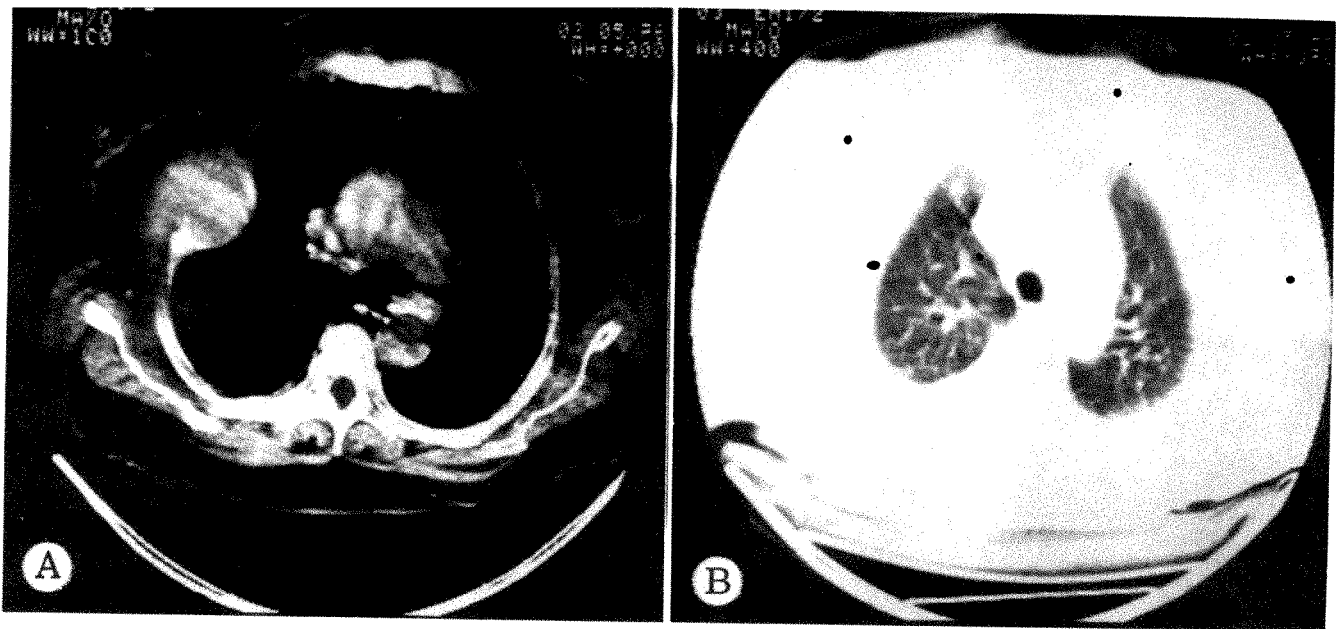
CT scans of 79-year-old woman who had subtotal thyroidectomy 3 years earlier for papillary adenocarcinoma. Destructive lesion had recently developed in right third rib and in right side of pelvis. *A*, Tomographic section through chest revealing large destructive lesion in rib on right. Large portion of mass projects into chest and tumor extends considerably into chest wall. *B*, Lung parenchyma revealed after adjusting window height and width. Note tiny nodule in apex of right lung anteriorly which was not appreciated on chest film.
